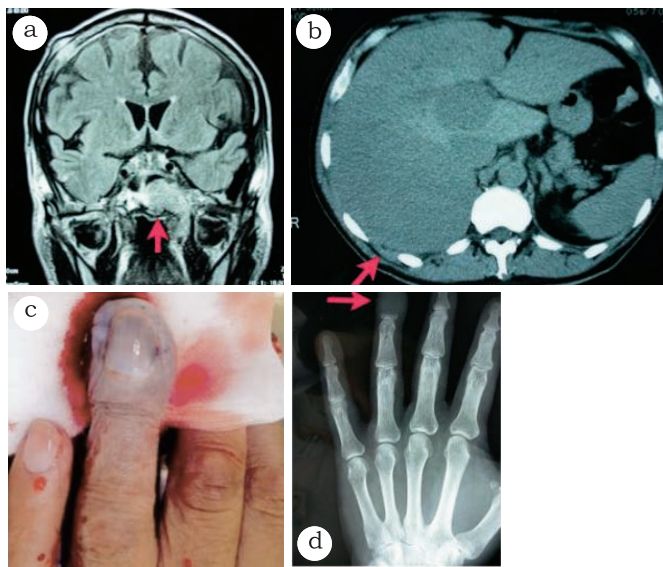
Imaging findings. (1a) Magnetic resonance imaging of the head: a $2 \times 2 \times 3$ -cm-sized mass was noted between the left wall of the nasopharynx and the sphenoid sinus (\leftarrow). (1b) Abdominal computed tomography: a 12-cm-sized mass was found in the right lobe of the liver (\leftarrow), and a 6-cm-sized mass was found in the porta hepatis. A 2.5-cm-sized mass was found near the head of the pancreas (data not shown). (1c) Necrosis was observed at the tip of the fourth finger of the left hand (\leftarrow). (1d) X-ray of the left hand showed osteolysis in the fourth finger distal to the distal interphalangeal joint (\leftarrow).
